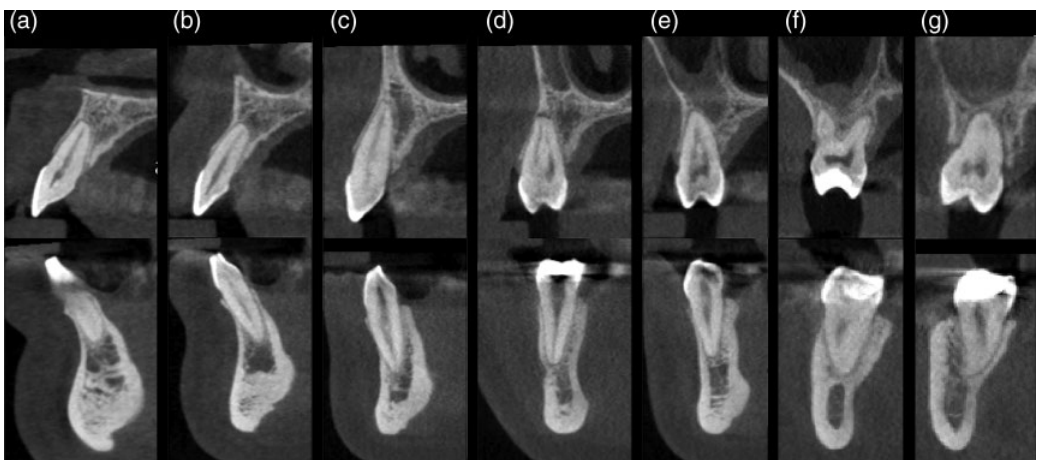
Periodontal ligament space. (a–e) Sagittal and coronal CBCT slices of the maxillary (top row) and mandibular (bottom row) anterior (a–c) and posterior (d–g) teeth. The slices accurately demonstrate the relationships of the roots of the teeth to the cortical plates as well as the orientation of the teeth within the jaws. Regional variations in jaw thickness and shape can also be readily appreciated.
